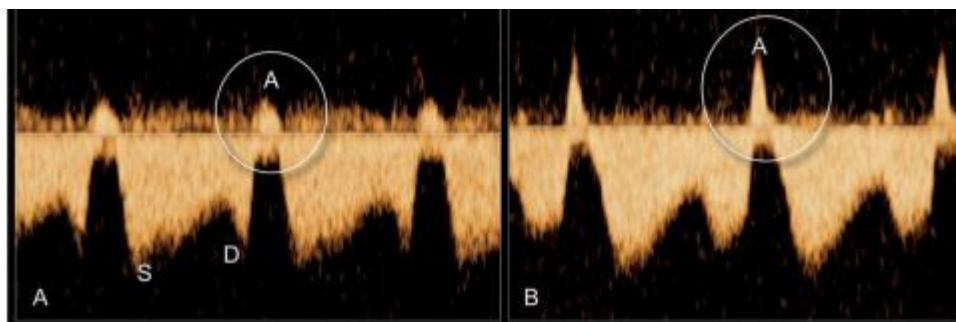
Pulsed doppler in two fetuses (A, B) at 13 week gestation with cardiac defect show reverse A wave. *Tricuspid Regurgitation (TR): may be seen in all gestational age and may be transient. TR seen at 11th – 13th week's gestation have an association with CHD [8].
